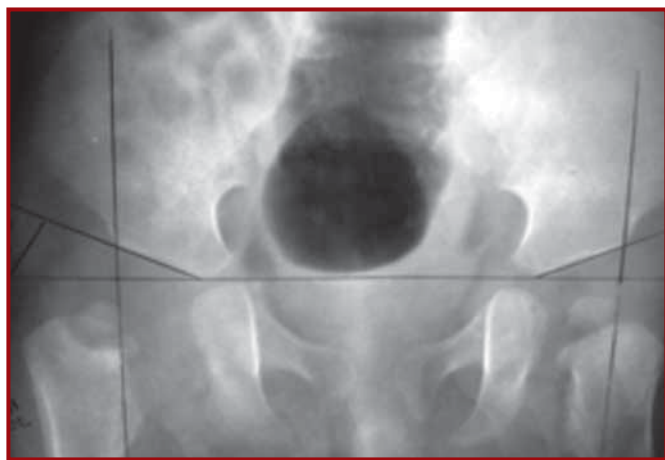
At the initial presentation to the department of orthopedics, radiograph of the pelvis demonstrates deformed proximal femoral metaphysis and small and low density dislocated femoral head on the right side, but similar acetabular development on both sides
